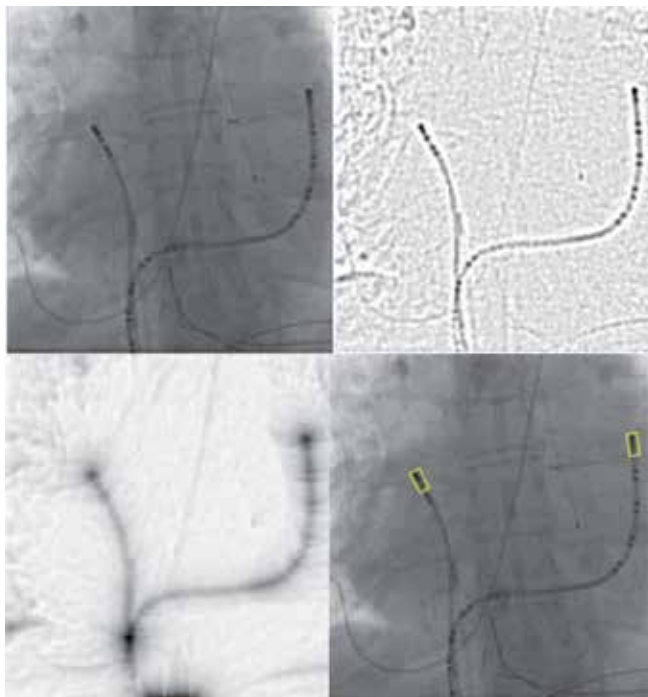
The original X-ray image with preprocessing (*top-row*) followed by geodesics properties computation. Final tip electrodes boxed in yellow (*bottom-row*).
